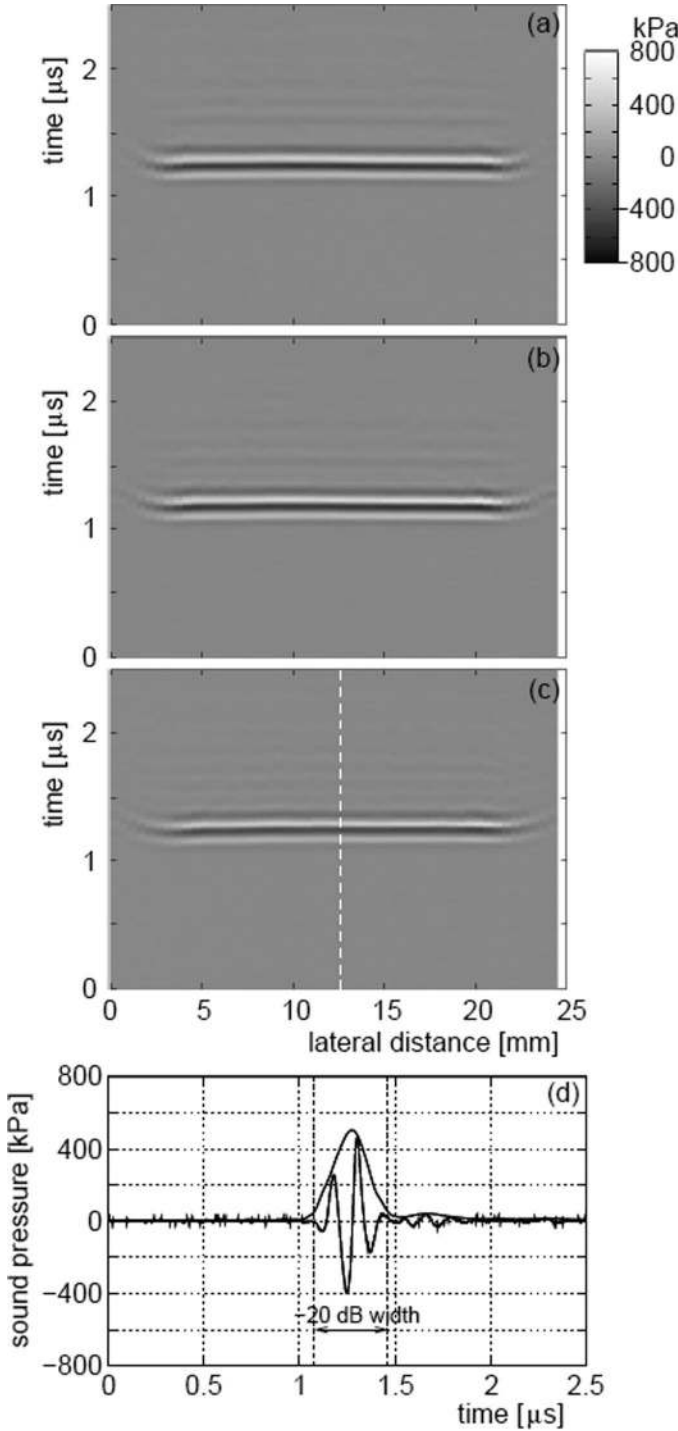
Ultrasonic RF signals measured by a hydrophone placed at distances between the linear array probe and the hydrophone of (a) 10 mm, (b) 15 mm, and (c) 20 mm. The hydrophone scans in the lateral direction using a stage. (d) Waveform of the RF signal and its envelope along the white dashed line in (c).
